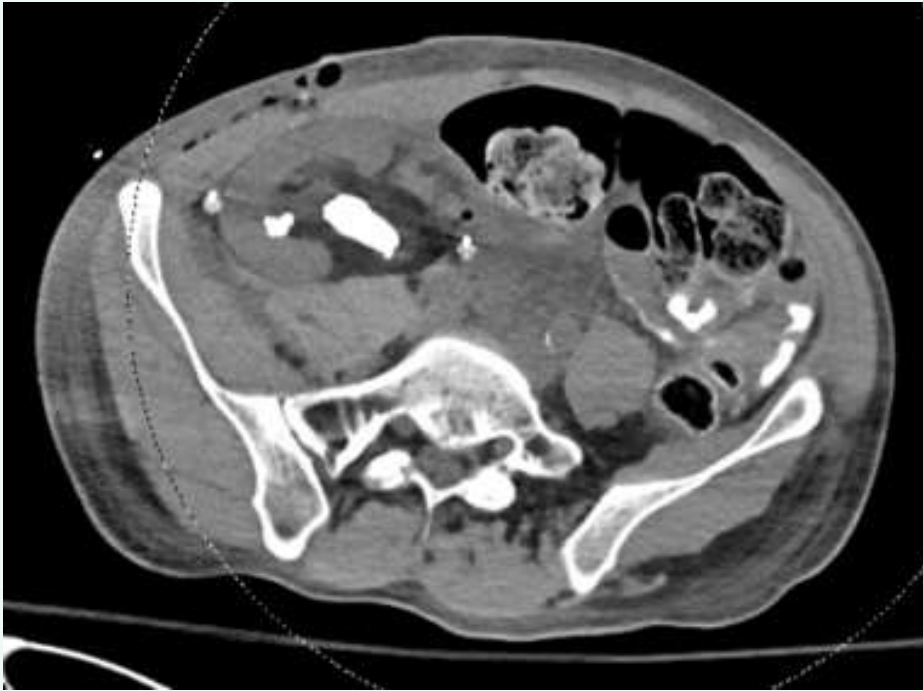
CT scan axial view depicting a large donor-gifted calculus.
